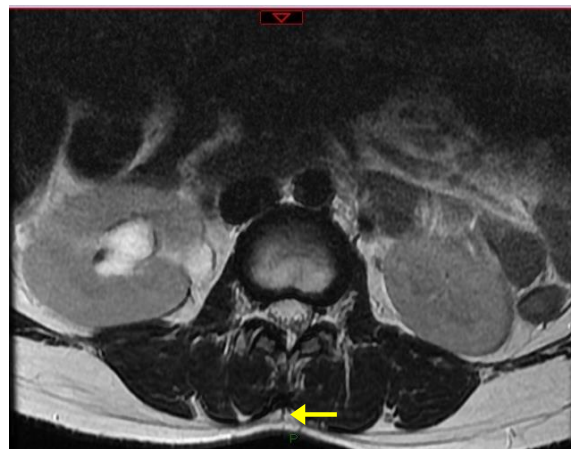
Suspicious signal in thoracolumbar spine MRI
